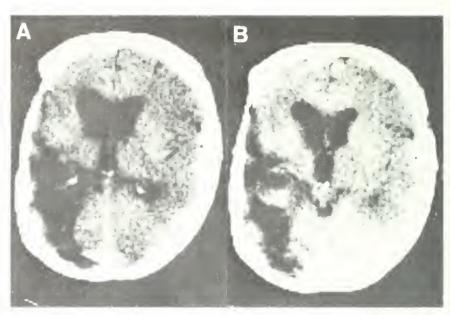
Enhanced CT scan of patient #3 with recurrent Glbm in the left parieto-temporal region. A before ultrasound was applied over the lesion. B immediately after the application of Iow intensity non-focused ultrasound at 1.5 watts/1 cm² for five minutes, showing increased enhancement, presumably due to increased permeability of the membranes of the neoplastic cells.
